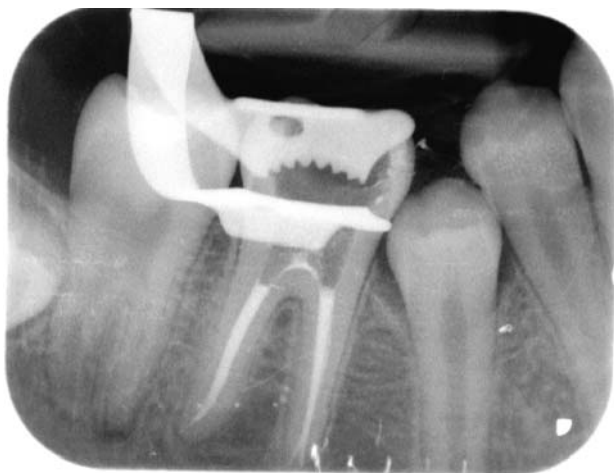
First postoperative radiograph of the root canal obturation.
